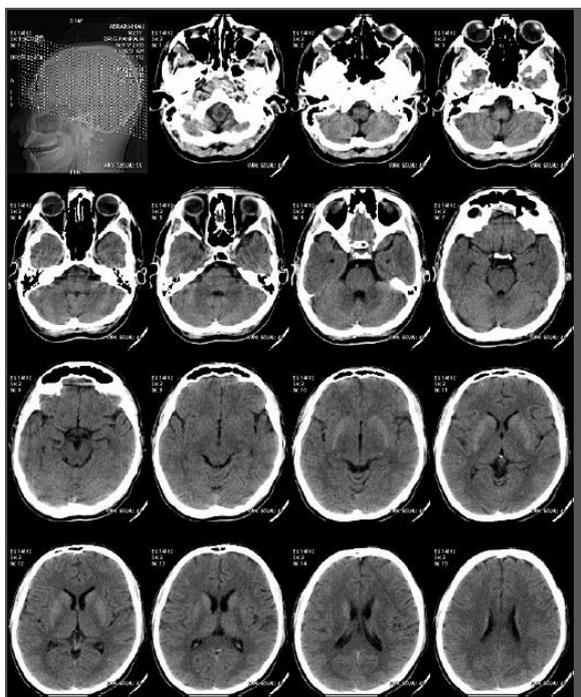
CT brain shows involvement of bilateral basal ganglia hyperintensities suggestive of hypoxic insult.
